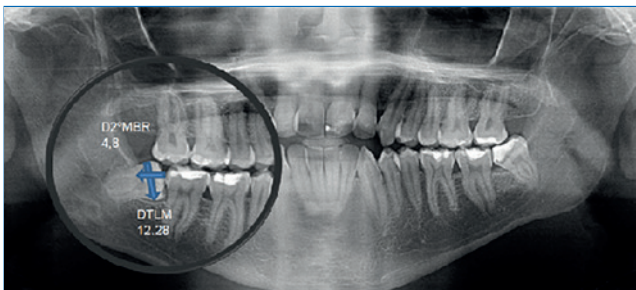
Digital orthopantomogram shows linear measurements realized. DTLM: Diameter crown of the third lower molar. D2°MBR: Distance between the distal border of the second molar crown and the anterior border of the ramus.
